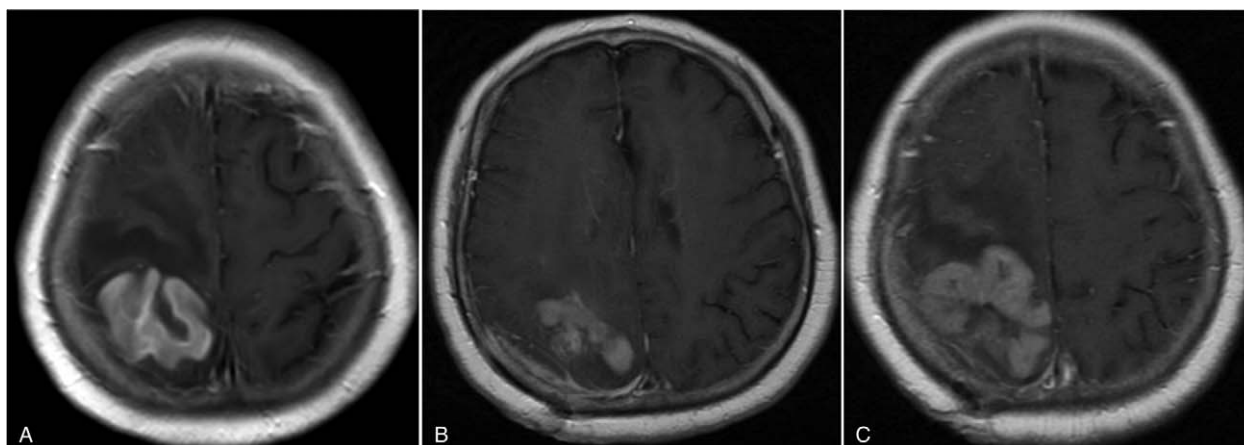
Magnetic resonance images of the tumoral lesion in the right parietal lobe before surgery (A); recurrence of the tumor mass at 1 month after surgery (B); and progression of the brain lesion after chemotherapy (C).
